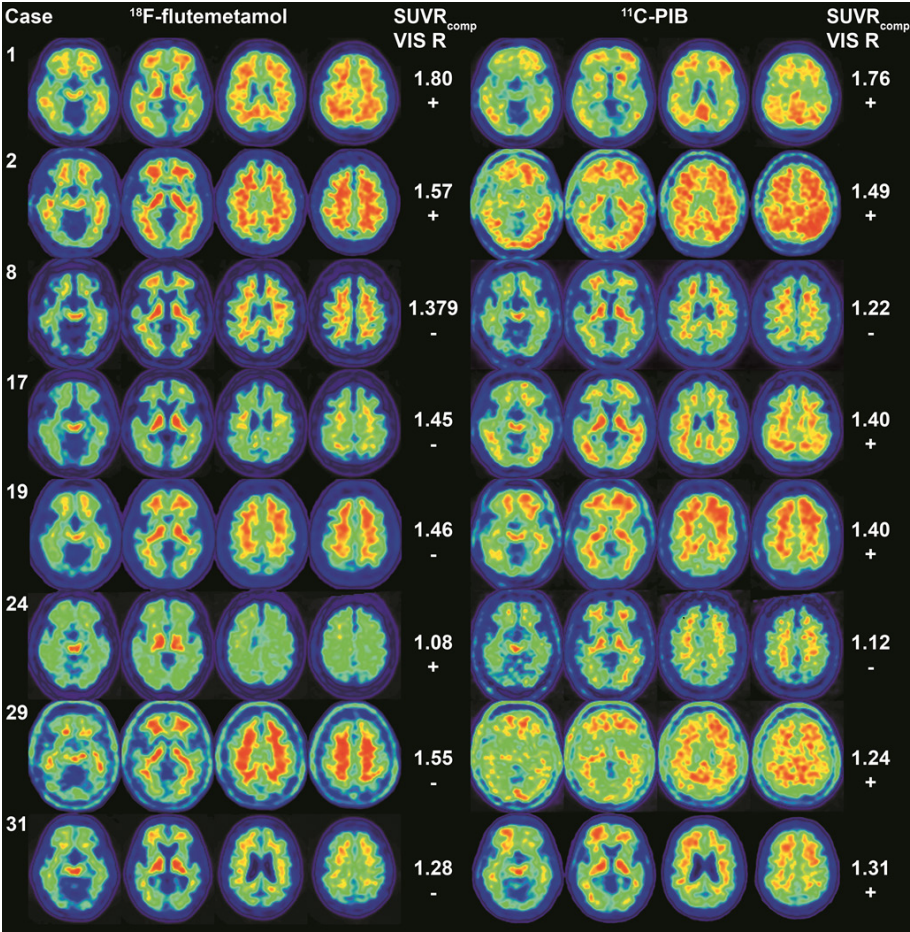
Representative summed PET images of the discordant cases between ^{18}F -flutemetamol and ^{11}C -PIB scans based on semiquantitative and visual classification. For the sake of comparison we also displayed two positive cases who were concordantly classified by semiquantitative and visual approach. Brain sections show axial slices at -4, 10, 24, 38 MNI z coordinates. On the right side of the brain sections $\text{SUVR}_{\text{comp}}$ values (at the top) and results of visual reads (VIS R, at the bottom, + positive scan, - negative scan) are shown. Images are scaled to a maximum intensity in an image.
